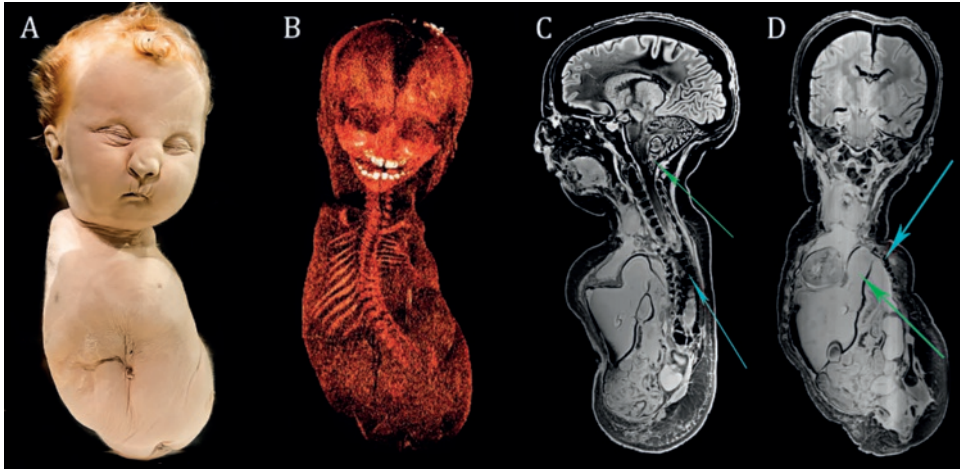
[A] Photograph of the full-term fetus of case 4. [B] 3D reconstructed skeleton based on the CT data. Although there was severely diminished bone calcification, CT images visualized small pelvic bones, partial absence of the sacral bone and a thoracolumbar convex shaped curvature. The scapulae and clavicles were normally developed with absence of the humeral, ulnar and radial bones including the hands. In addition, the femora, tibial and fibular bones including the feet were absent. [C] Sagittal T1-weighted MR image showed an Arnold-Chiari malformation (green arrow) and distorted vertebral column (turquoise arrow). [D] Coronal T1-weighted MR image showed a severe diaphragmatic hernia (green arrow) which deviated the heart completely to the right lateral thoracic wall. The left pleural cavity was almost entirely occupied by the liver, stomach, spleen and left adrenal gland, the left lung was merely noticeable. Moreover, a distortion of the left ribs was seen (turquoise arrow).
